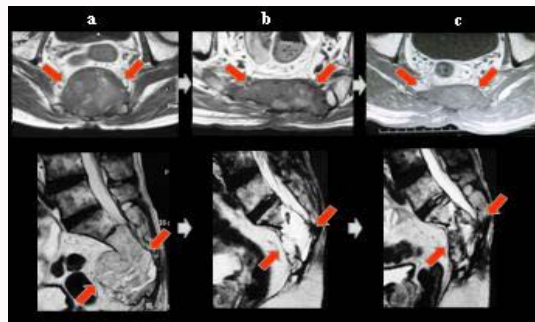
a: Before CIRT. A T2-weighted image on examination demonstrated large sacral chordomainvasing up to S2; b: 3 years after CIRT; c: 5 years afret CIRT.
